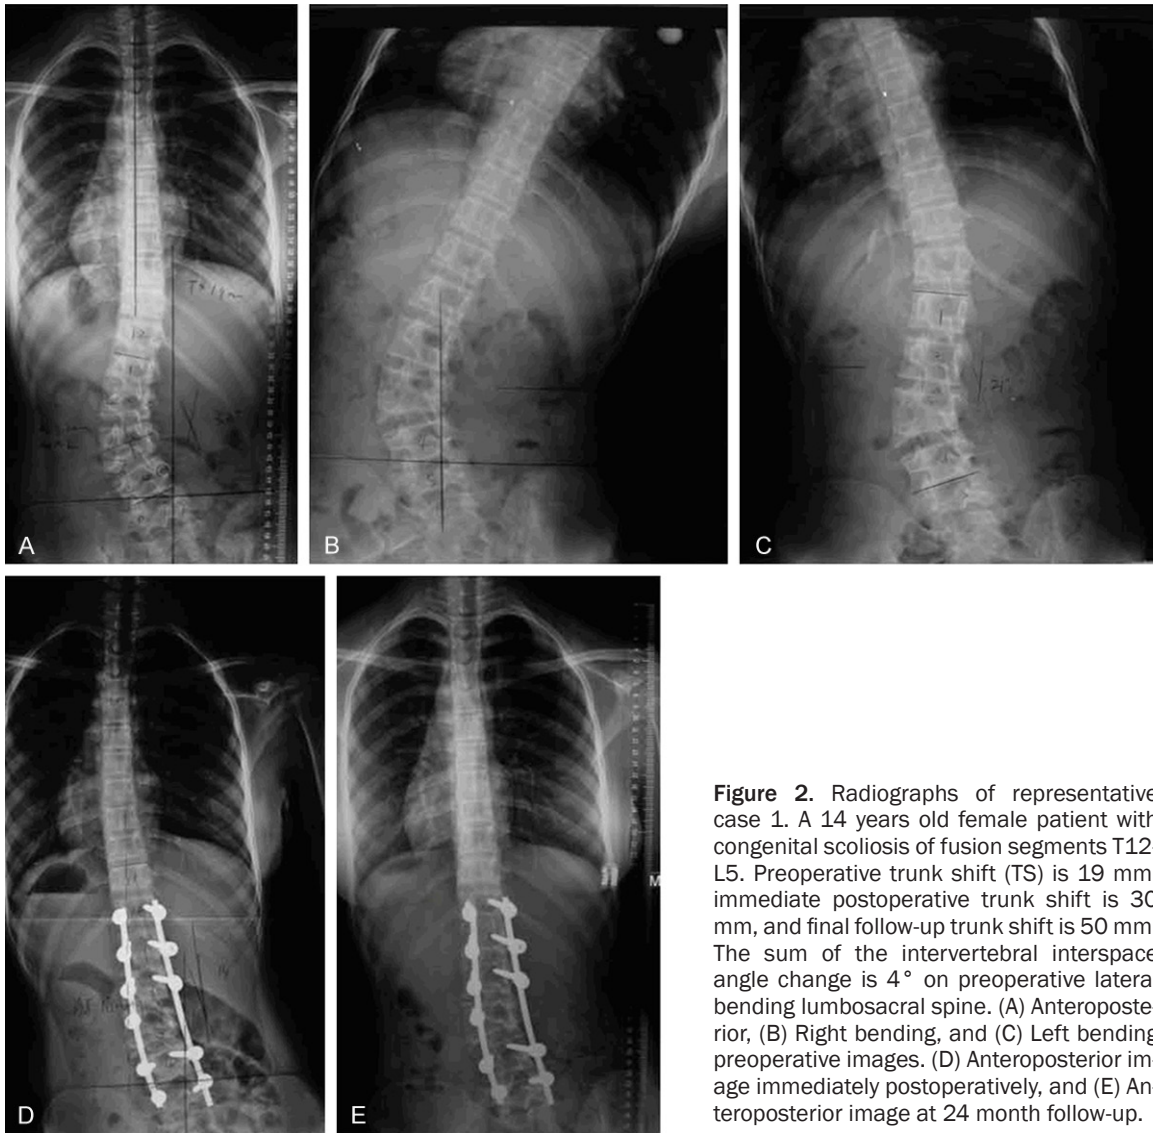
Radiographs of representative case 1. A 14 years old female patient with congenital scoliosis of fusion segments T12-L5. Preoperative trunk shift (TS) is 19 mm, immediate postoperative trunk shift is 30 mm, and final follow-up trunk shift is 50 mm. The sum of the intervertebral interspace angle change is 4° on preoperative lateral bending lumbosacral spine. (A) Anteroposterior, (B) Right bending, and (C) Left bending preoperative images. (D) Anteroposterior image immediately postoperatively, and (E) Anteroposterior image at 24 month follow-up.
